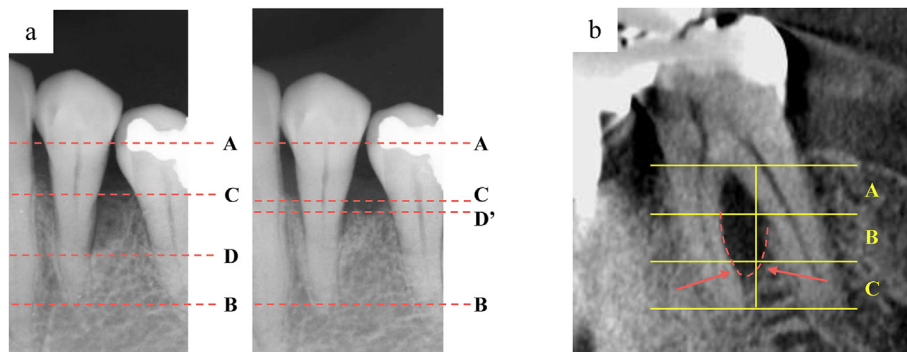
a. Measurement of the percentage of bone fill is determined using standardized dental x-ray images. Points A, B, C, D, and D' correspond to the cemento-enamel junction (CEJ), the root apex, the remaining alveolar bone crest, and the bottom of the bone defect at baseline and reevaluation, respectively. The increase in alveolar bone height is calculated with the formula: $(A-D) - (A - D') \times 100 / (C-D)$. The distance between the CEJ and the apex is used as a reference to correct for minor errors. b. The vertical subclassification of furcation involvement (FI) is assessed by examining a two-dimensional cross-section at the FI site. This is done by splitting the two roots nearest to the FI into two equal halves. This cross-section is then divided into three equal segments: the coronal third (subclass A), the middle third (subclass B), and the apical third (subclass C) of the root length. The severity of periodontal support loss is categorized into these three subclasses.
